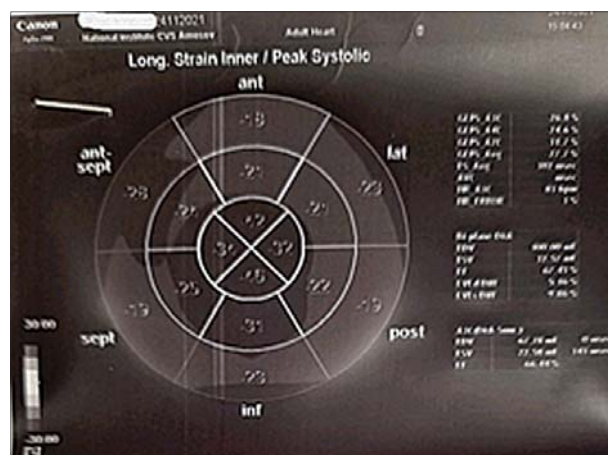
Result of 40 mg dobutamine stress echocardiography (after LMCA stent placement)
